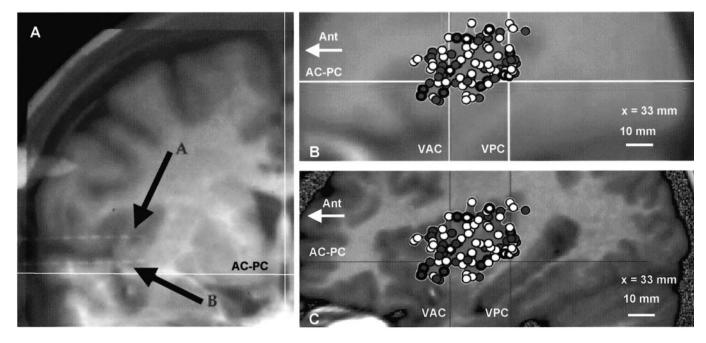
(A) Immediate post-implantation frontal X-ray showing the trajectory of the electrodes superimposed on the corresponding coronal section of the MRI. As can be seen, the first and second deepest contacts of the trans-opercular electrodes A and B (indicated by the arrows) are in the depth of the insular cortex. (B) A plot of all (93) stimulated insular sites on a sagittal section (x = 33 mm) of the insular cortex of the MNI standard brain. (C) A plot of all (93) stimulated insular sites on the corresponding sagittal section of the insular cortex of one of our patient's cerebral MRI, showing a similar sampling. Circles represent sites of stimulation, thick contours indicate sites where stimulation evoked a localized AD. AC-PC: horizontal plane passing through the anterior and posterior commissure; VAC: frontal plane passing trough the anterior commissure, perpendicular to the AC-PC plane; VPC: frontal plane passing through the posterior commissure, perpendicular to the AC-PC plane. The white line is the contour of the stimulated insular area. Open circles: insular sites in the right hemisphere; hatched circles: insular sites in the left hemisphere.
